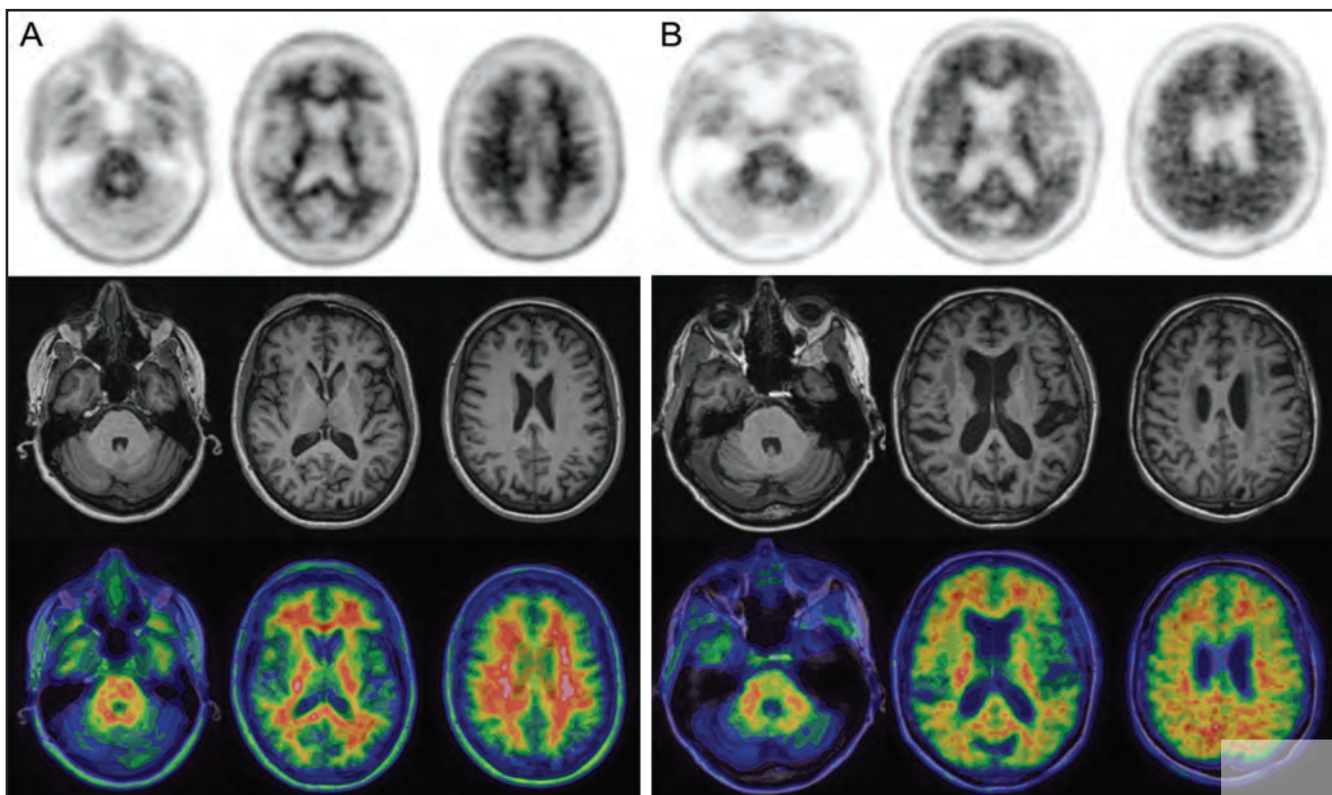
Amyloid imaging with F-18 florbetapir. Panel A shows a normal control subject with no-to-sparse beta-amyloid plaques. Panel B shows a positive PET/MRI study, consistent with moderate to frequent beta-amyloid plaques.
